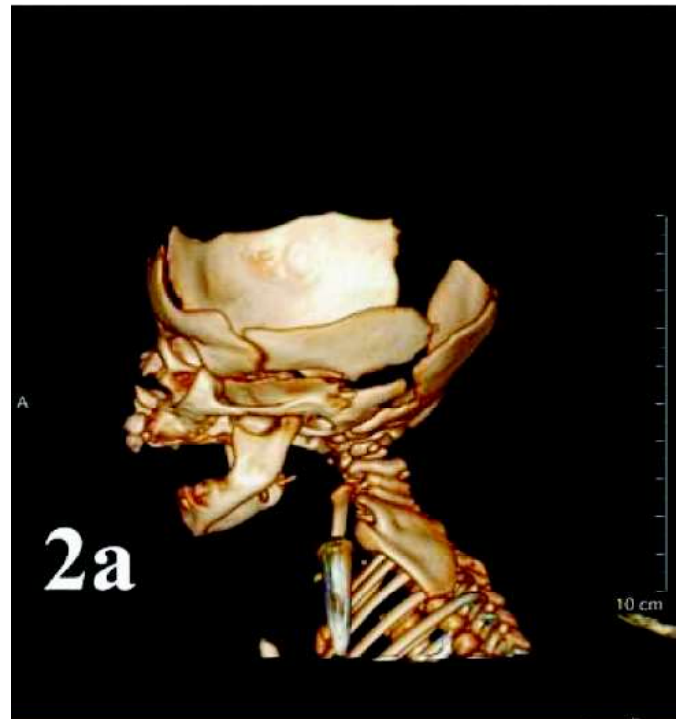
CT scan with 3D imaging showing acrania
